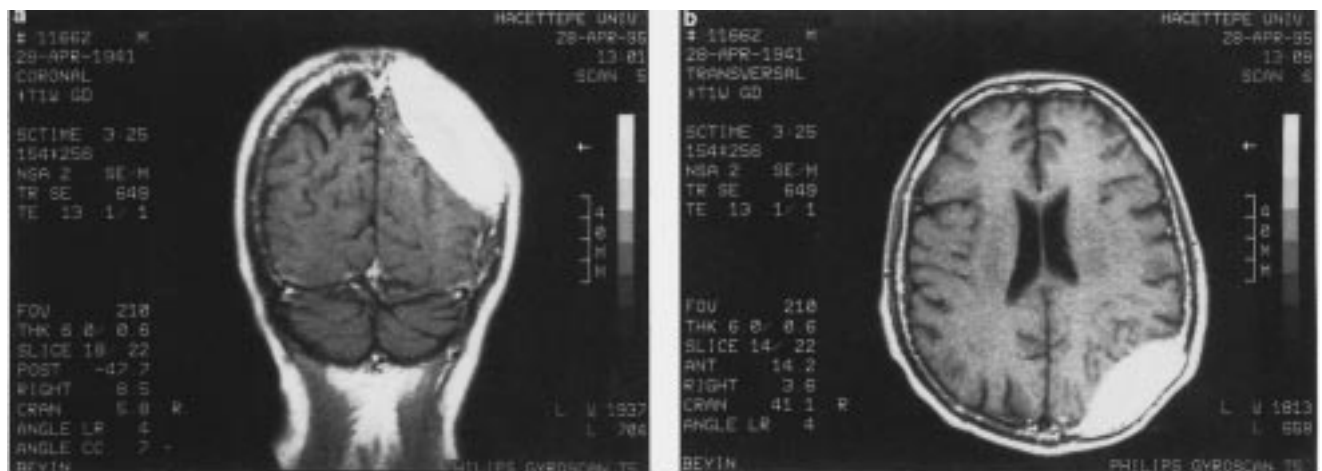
Extraaxial bulky mass of the skull with intracranial involvement is shown in T1-weighted magnetic resonance coronal (a) and transverse (b) images with intense contrast enhancement.
